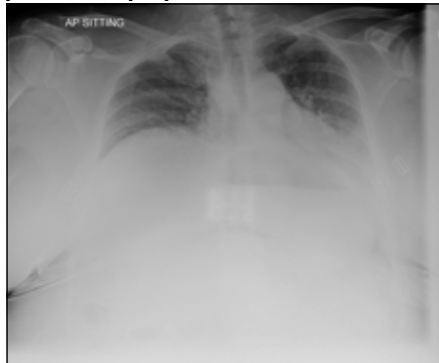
Chest X-ray after 24 hours showing resolution of right phrenic nerve palsy.
